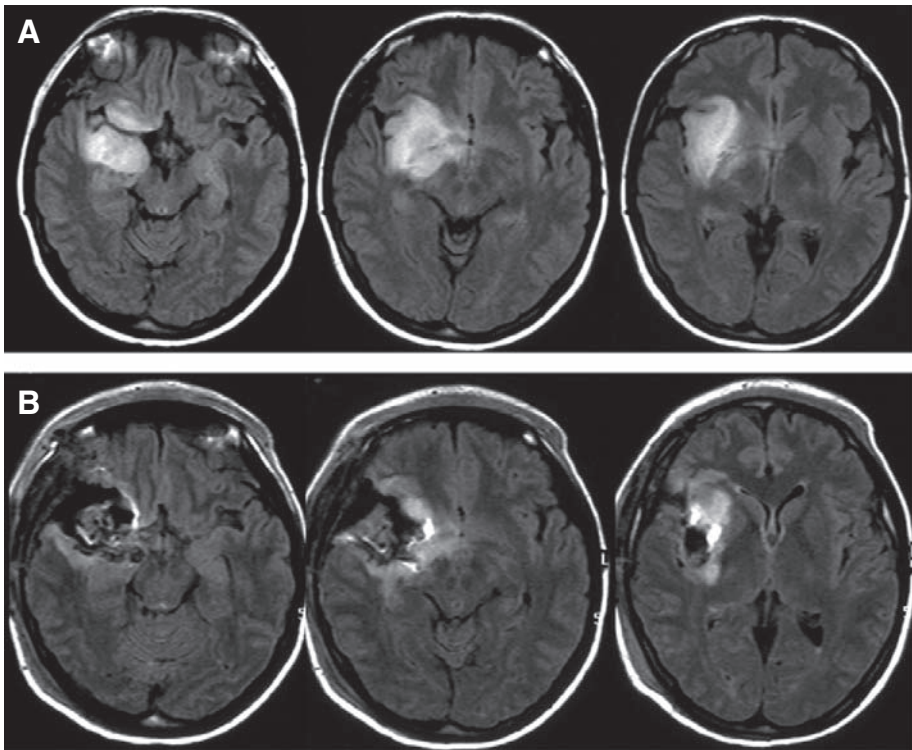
A) Preoperative FLAIR images of a right paralimbic (insular) astrocytoma WHO grade II. The 40 year old female patient presented with a history of two generalized seizures and multiple complex partial seizures. The tumor involves the uncus but not the hippocampus (Yasargil type 5A). There is also minor tumor growth in the frontoorbital area. B) Postoperative FLAIR images depict a $>70\%$ resection of the tumor. There was no postoperative neurological deficit. At the most recent (three year) follow-up there was no tumor progression. The patient reported occasional auras but no complex partial or generalized seizures. Her antiepileptic medication is currently switched from carbamazepine to levetiracetam because of protracted leucopenia (see Table 1 for side effects of common anticonvulsants). (Dr. Neuloh, Dept. of Neurosurgery, Univ. of Bonn, helped with the preparation of this figure)
